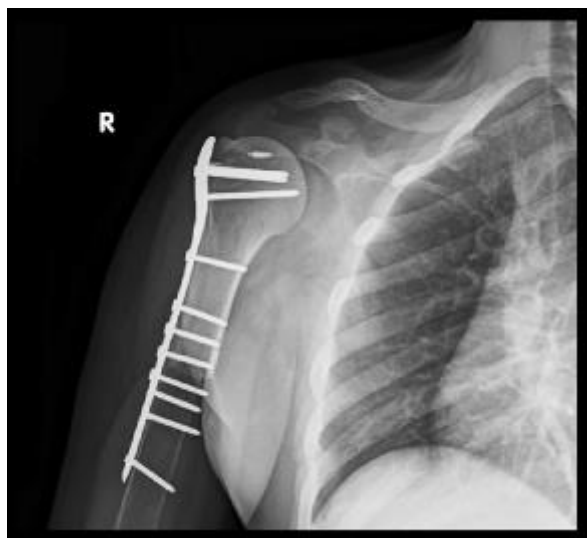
Postoperative radiograph showing a proximal humerus allograft fixed with a proximal humerus locking plate and an anchoring system for reinsertion of the joint capsule and rotator cuff.
